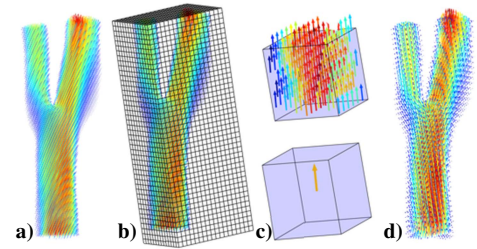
a) CFD velocity data b) MRI grid on CFD data. c) averaging of CFD velocity to MRI resolution d) CFD velocity data at MRI resolution
